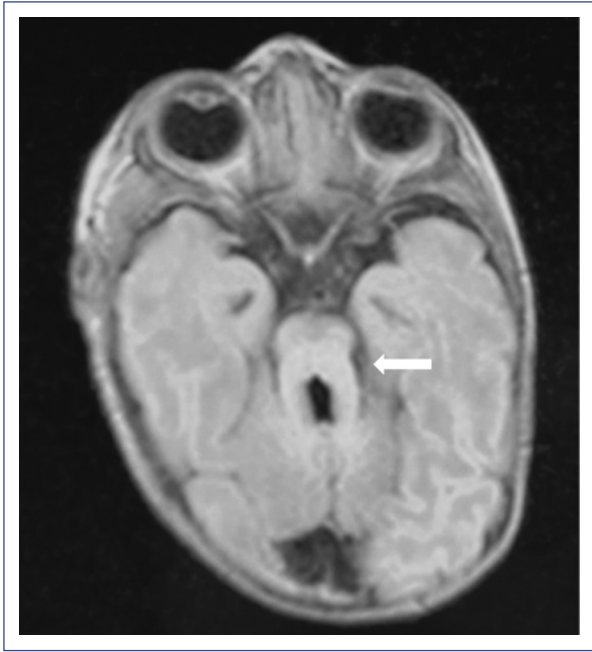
Brain MRI, axial plane, T1-weighted. There is a classic aspect of molar tooth of the midbrain secondary to thickening and elongation of the superior cerebellar peduncles.
